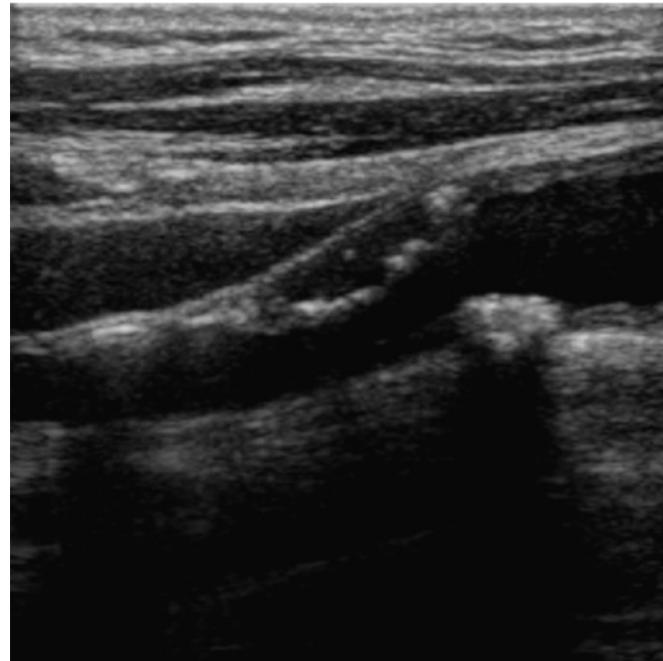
B-mode ultrasound image of carotid stenosis. The top part is echolucent, indicating a high content of lipid/necrotic core; the bottom part is echogenic, indicating a fibrous plaque.
